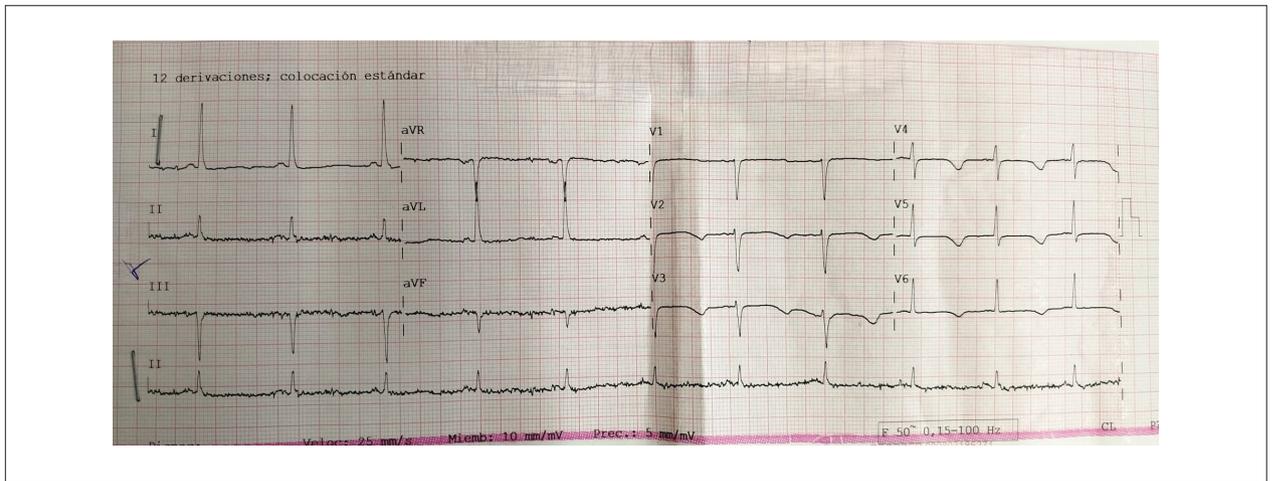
Echocardiogram showing sinus rhythm, narrow QRS complexes, diffuse inverted T waves and a QTc of 700 ms.
